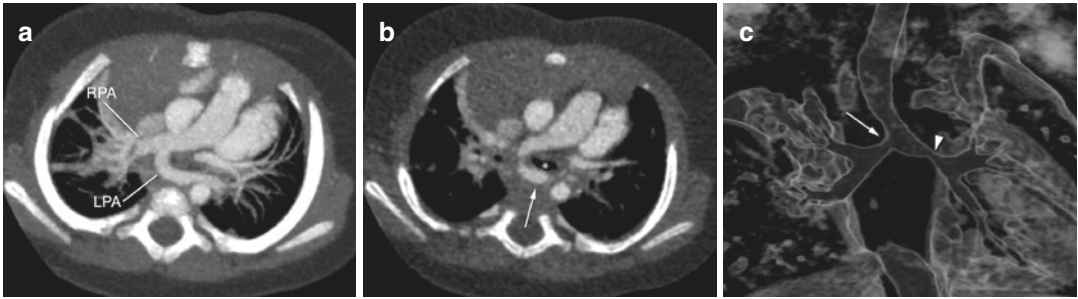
Pulmonary artery sling. CT angiography in a 2-year-old boy with pulmonary artery sling. (a) The left pulmonary artery (LPA) originates distally from the right pulmonary artery (RPA). (b) The LPA (arrow) encircles the trachea (asterisks) and courses in front of the oesophagus.
